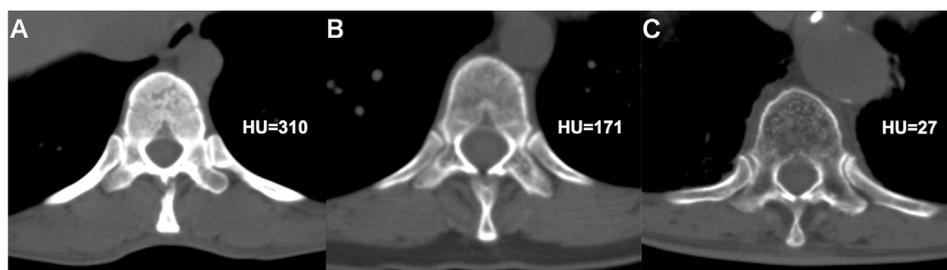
Cross-sectional CT images at the level of the eleventh thoracic vertebra. Examples in three patients with different BMDs. A) A 45-year-old female with high BMD (310 HU). B) A 69-year-old male with normal BMD (171 HU). C) An 82-year-old male with low BMD (27 HU). BMD, bone mineral density; CT, computed tomography; HU, Hounsfield unit.
